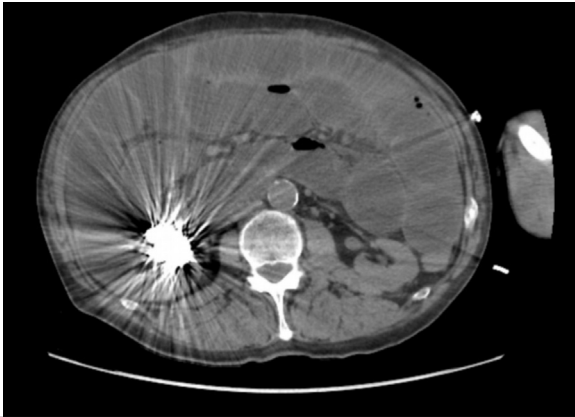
Computed tomography shows massively dilated small bowel and foreign body in the right lower quadrant.
